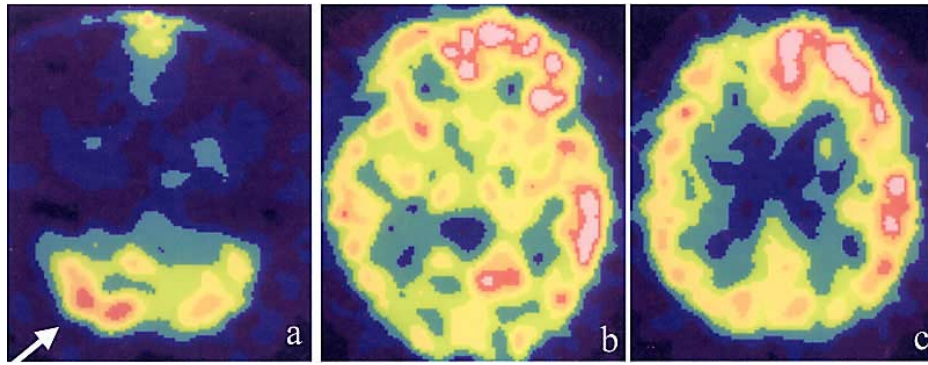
(a–c) SPECT images at 7 days after onset showed wide increased uptake in the mainly left frontal lobe, left insula and the right cerebellar hemisphere (*arrow*).
